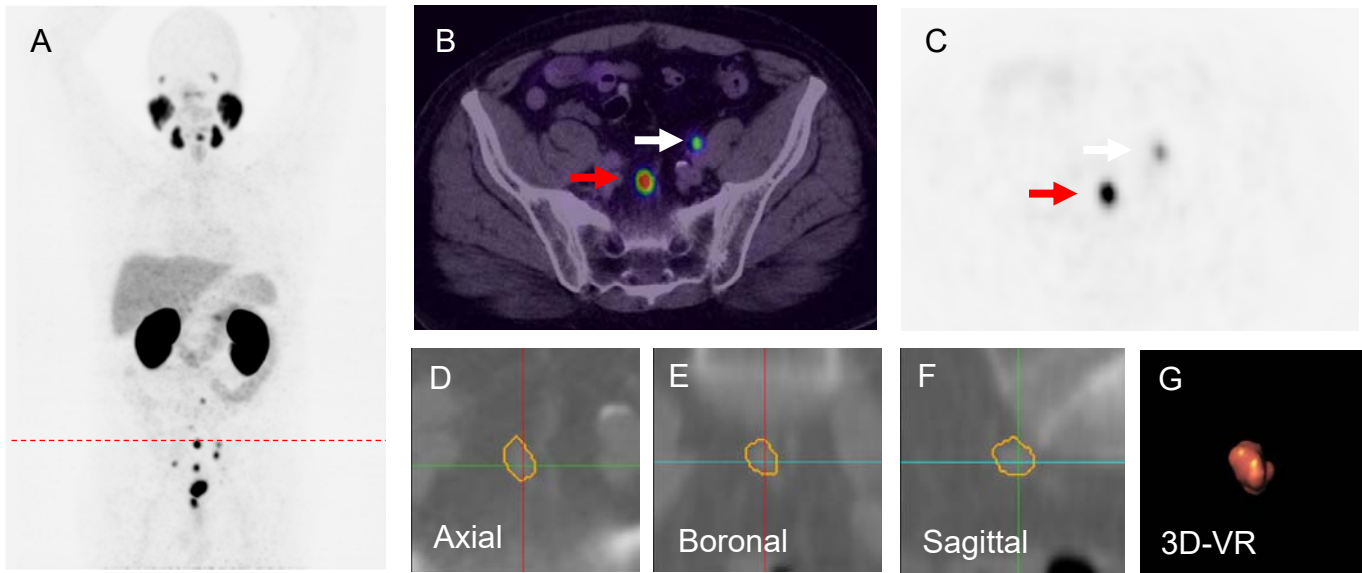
A 66-year-old patient with PSA relapse of 9.1 ng/mL, 5 years after radical prostatectomy (Gleason score 9, initial PSA level 69.9 ng/mL). The ^{68}Ga -PSMA PET maximum intensity projection demonstrates multiple positive nodes in the pelvic and abdominal region (a). Single axial PET/CT image (b) presents two PSMA-positive nodes (arrows). The node pointed by red arrow (c) with SUVmax 36.32 was segmented using Fraunhofer MEVIS software. The software enables automatic quantification of the dimensions based on axial (d), coronal (e) and sagittal planes (g) of CT-images (short-axis diameter 7.57 mm, long-axis diameter 11.35 mm, volume 0.5 ml). Image (g) shows 3D-volume rendering which also provided by the software.
